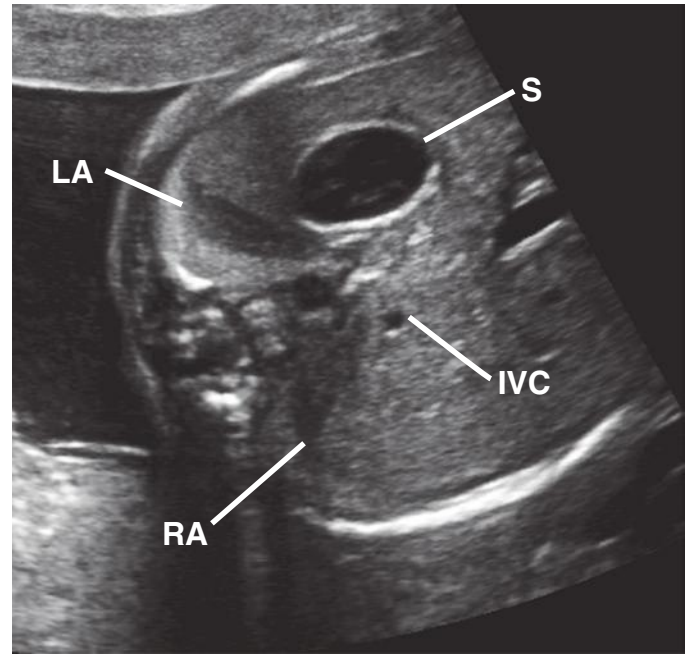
Transverse axial sonogram of the adrenal glands; much anatomy can be seen on this image of the upper fetal abdomen. Note both limbs of the right adrenal gland (RA) immediately posterior to the inferior vena cava (IVC), and the left adrenal gland (LA) is to the left of the aorta and posterior to the stomach (S). See also Figure 8-6 for the typical triangular appearance of the adrenal gland in the coronal plane superior to the kidney.
